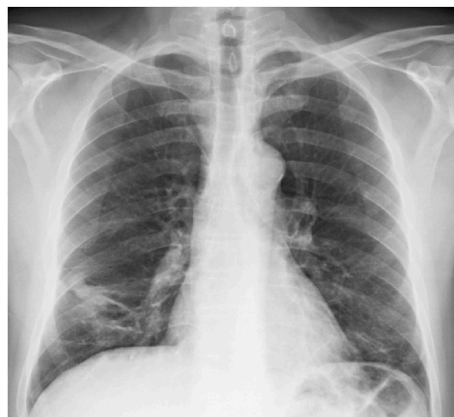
The patient's chest X-ray was taken because of the suspicion of pneumonia. The posteroanterior (PA) views of the chest radiograph show the presence of an area of parenchymal radiopacity, with the bronchovascular bundles thickening in the right suprabasal region (white arrow).
